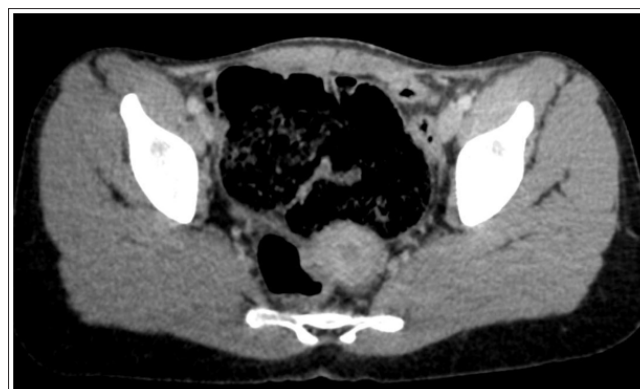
Enhanced abdominal CT scan (axial) showing a megacaecum descending in the pelvis, with significant arial distension and fecal stasis, with no evidence of mechanical or functional obstruction distally
